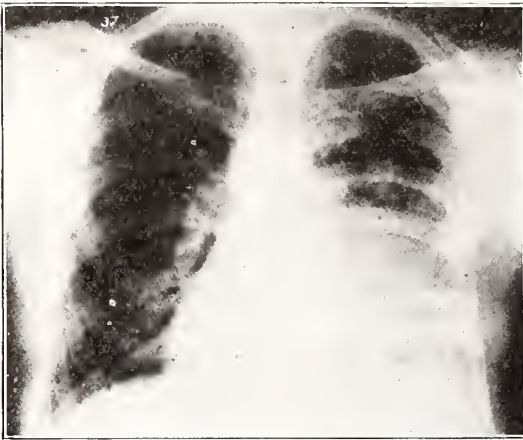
Radiograph showing pulmonary abscess of the right lower lobe.
